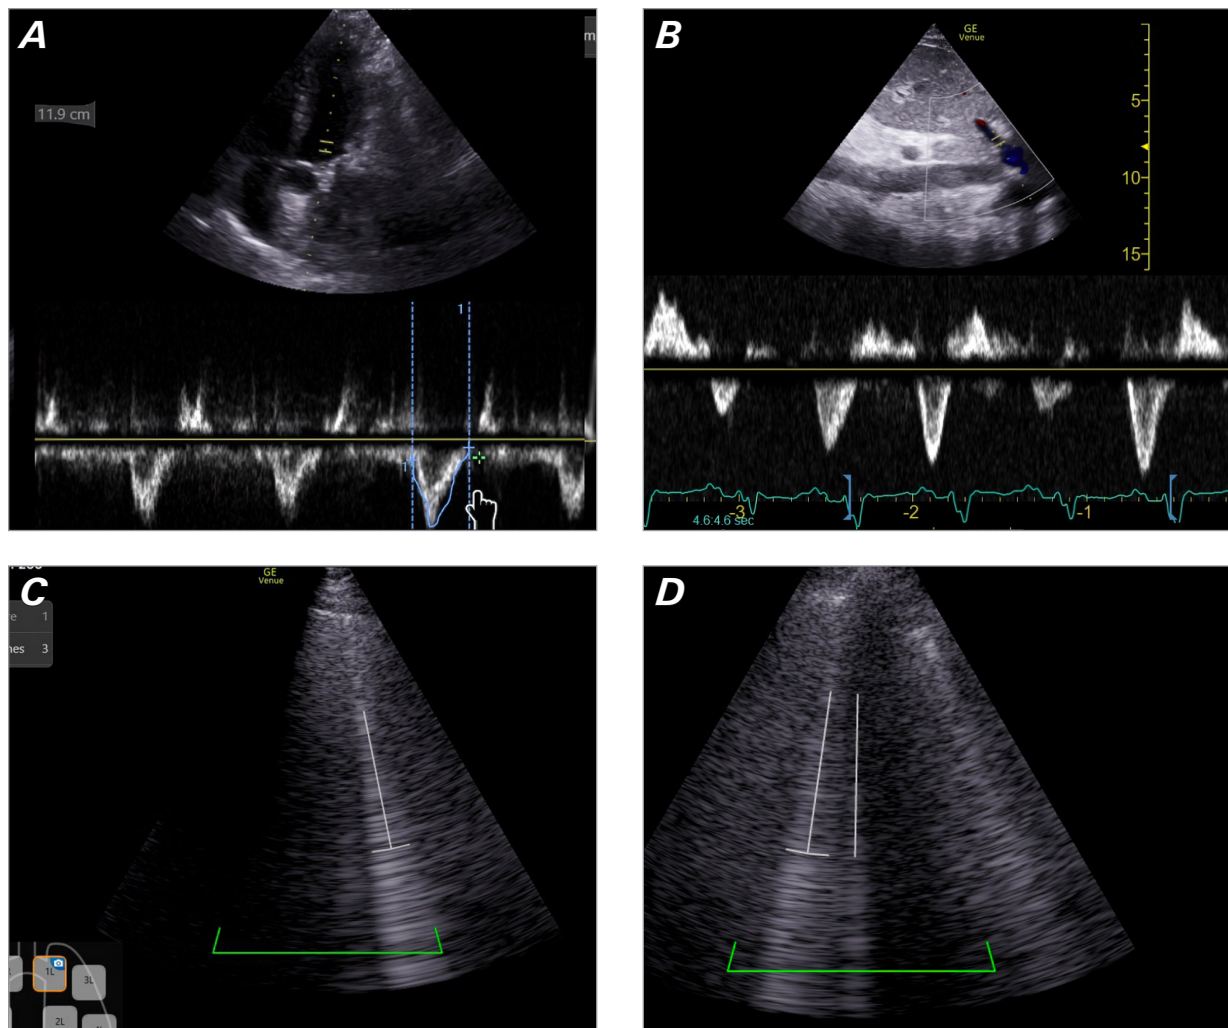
Transthoracic echocardiogram from case 1. A) Pulsed-wave Doppler in apical 5-chamber view with left ventricular outflow tract velocity time integral measuring 12 cm, with correct position and angle. B) Hepatic vein Doppler showing systolic flow reversal. C,D) Lung ultrasonography views demonstrating increased B lines in bilateral upper lung fields.
